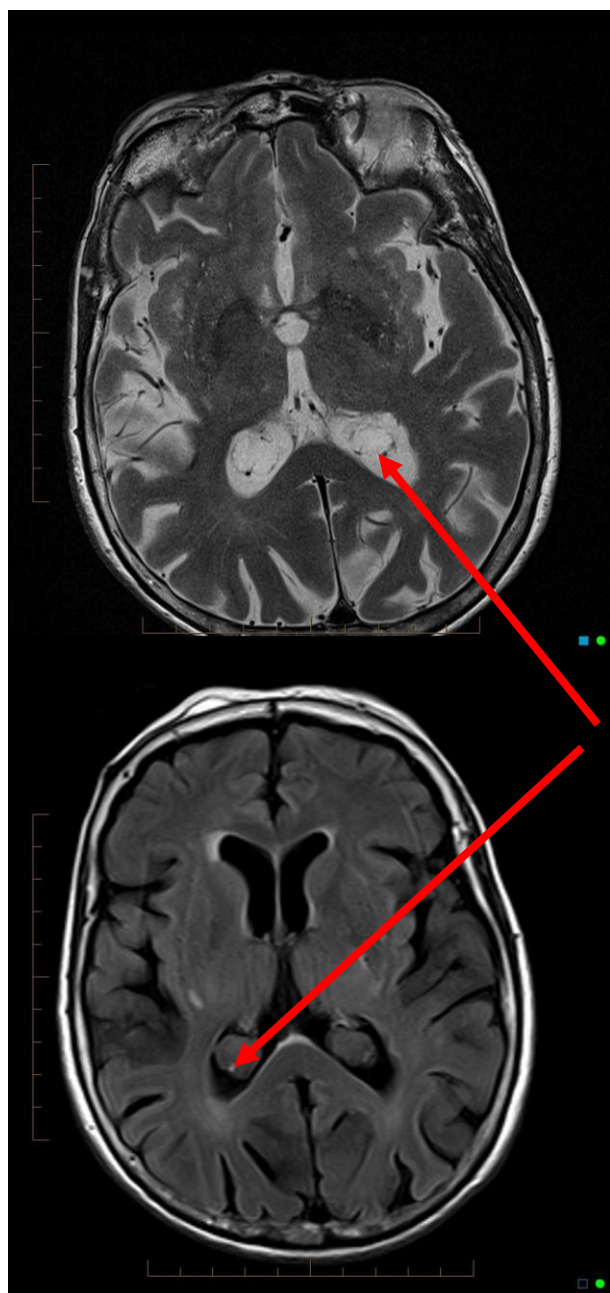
MRI Brain: Abnormal high signal intensity lesion noted involving bilateral choroid plexus of occipital horn of lateral ventricle on T2WI which appear hypointense on T1W1, FLAIR and shows diffusion restriction on DW1 sequence. Size measuring approximately 1.6×1.1 cm on Right side and 1.2×1.2 cm on left side, possibility of xanthogranuloma of occipital horn of bilateral choroid plexus (Arrow).
